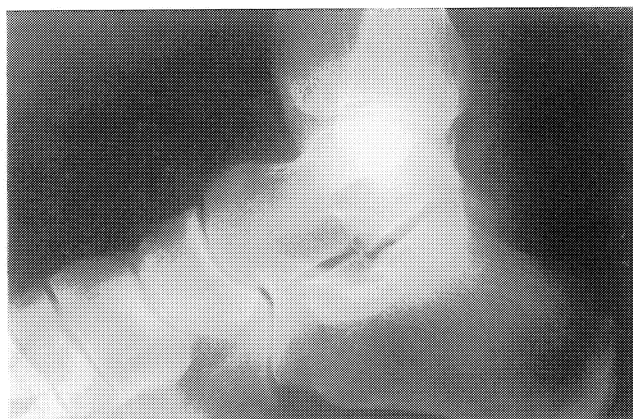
50 year-old patient with progressive heel pain. Figure 1A. Initial lateral radiograph of the heel is normal.
